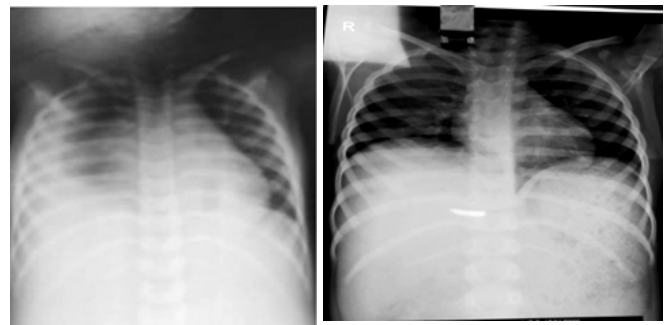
Showing the improvement in chest x-ray, within one day, after treating the patient as per severe Covid guidelines.
